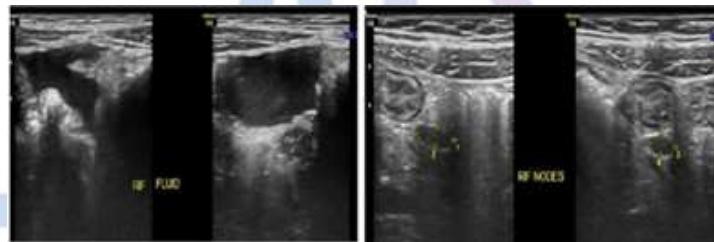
(A, B). 9 year female child with sonogram of right lower quadrant shows focal free fluid & lymph Nodes adjacent to the echogenic bowel loop. The Appendix is not seen (Grade 3).
